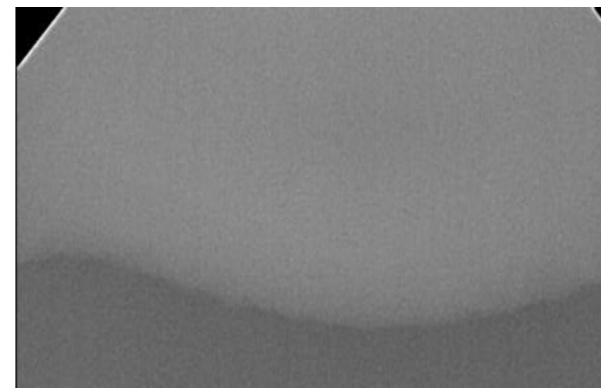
Upper lip radiograph
